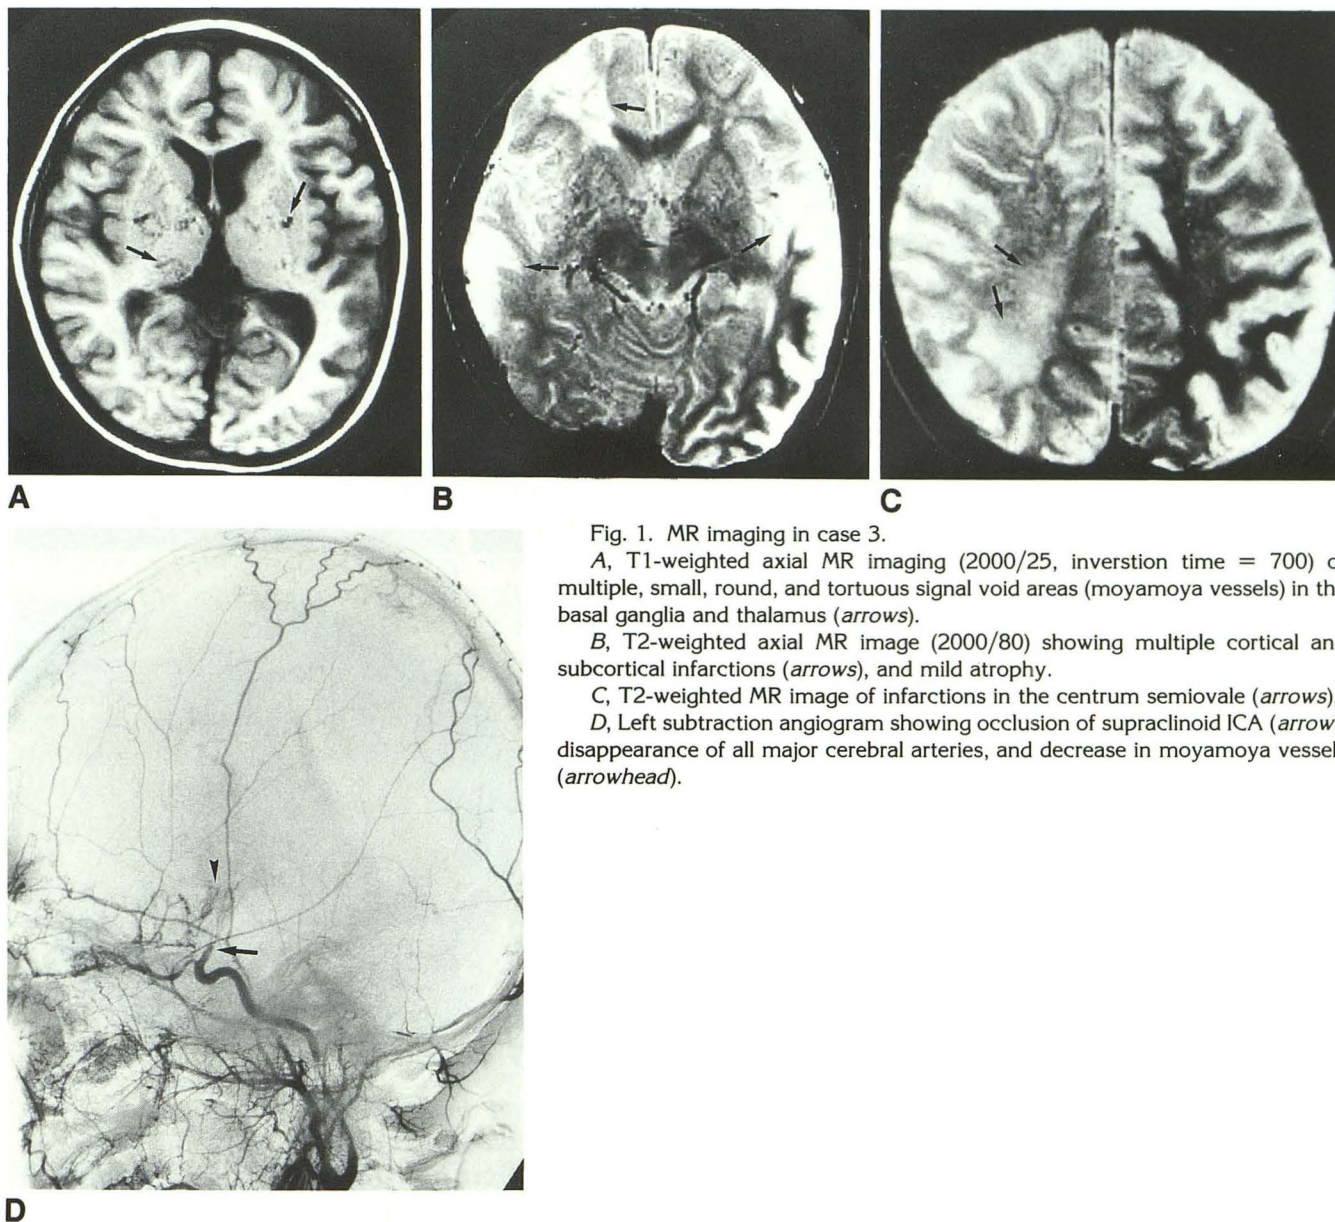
MR imaging in case 3.
